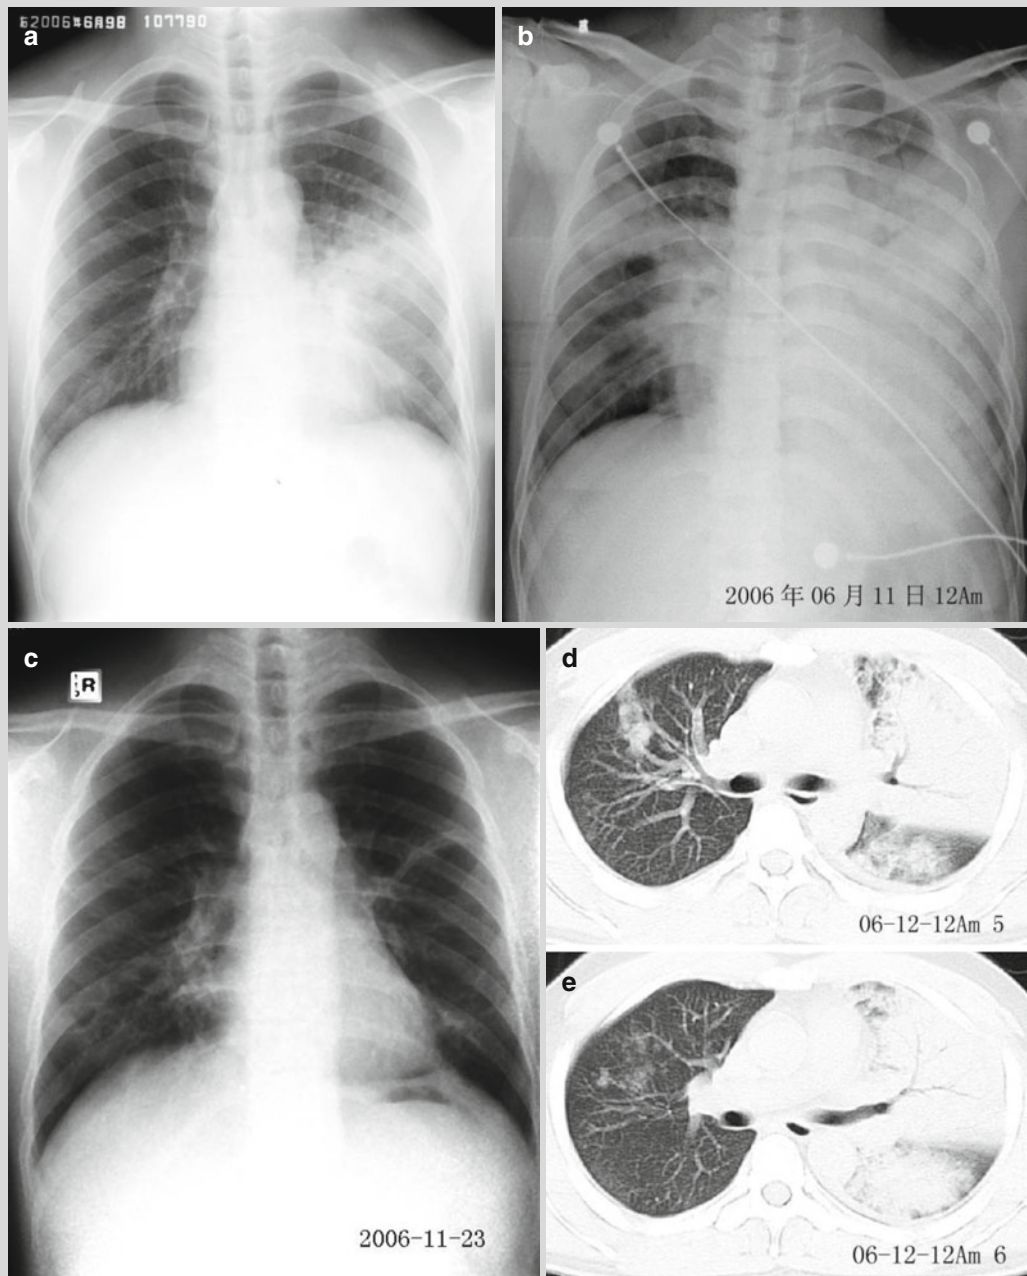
(a) On d 6 after onset, chest X-ray demonstrated poorly defined large flakes of increased density opacity at the left middle and lower lung fields, and some of the lesions showed ground glass opacity. (b) On d 8 after onset, chest X-ray reexamination demonstrated rapid progression of the lesions, with large flakes of increased density opacity at the whole left lung fields in white-lung sign. Flakes of increased density opacity were revealed at the right hilum area of right middle lung field and middle-medial zone of right lower lung field. (c) On d 20 after onset, chest X-ray reexamination demonstrated sporadic spots and cords like increased density opacity in both lungs, with well defined boundaries. (d, e) On d 7 after onset, CT scan showed light small flakes of opacity at the posterior segment of right upper lung lobe and medial segment of the right middle lung lobe. Irregular small flakes of consolidation was revealed at the apico-posterior segment and anterior segment of left upper lung lobe. Large flake of dense opacity of consolidation was also revealed at the lingual segment of the upper lung lobes and most of the lower lung
